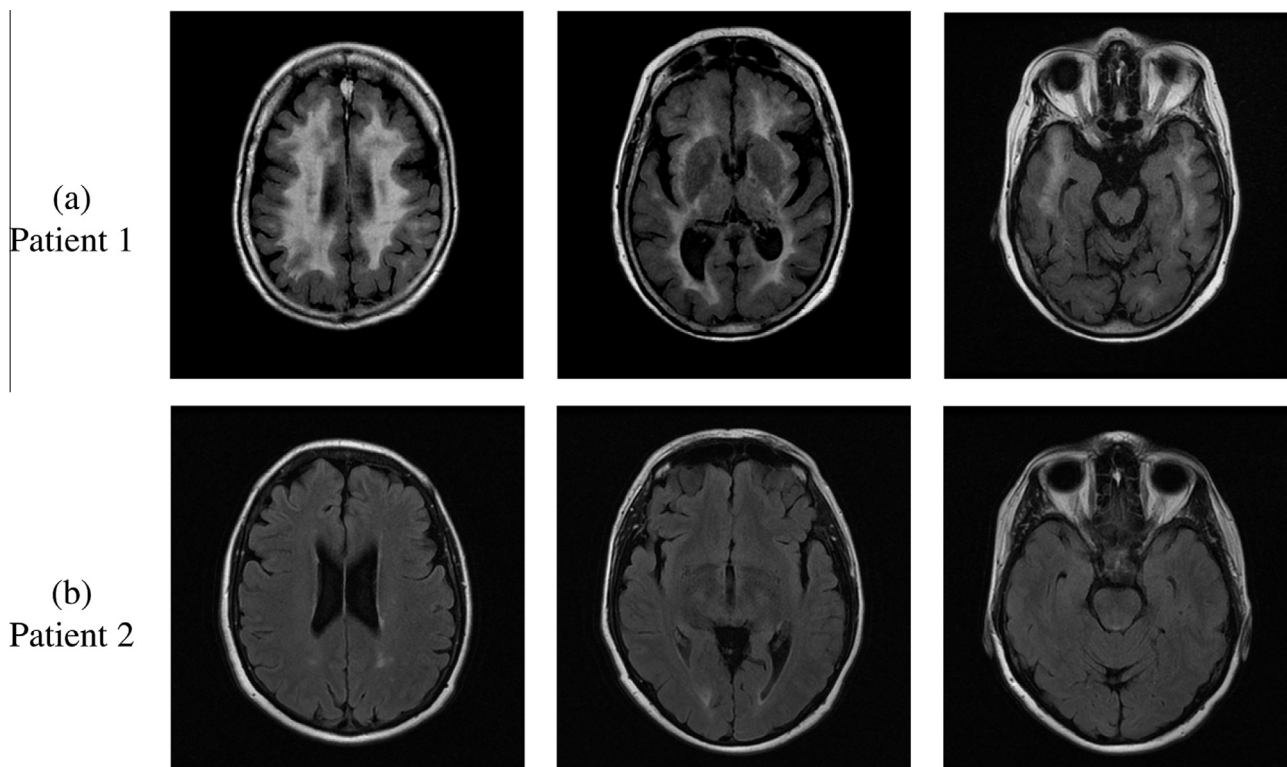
Transverse fluid attenuated inversion recovery MRI in (a) Patient 1 showing striking and extensive confluent high signal change affecting the white matter of both cerebral hemispheres, and (b) Patient 2 showing more subtle changes, with hyperintense foci in the subcortical and periventricular white matter.
